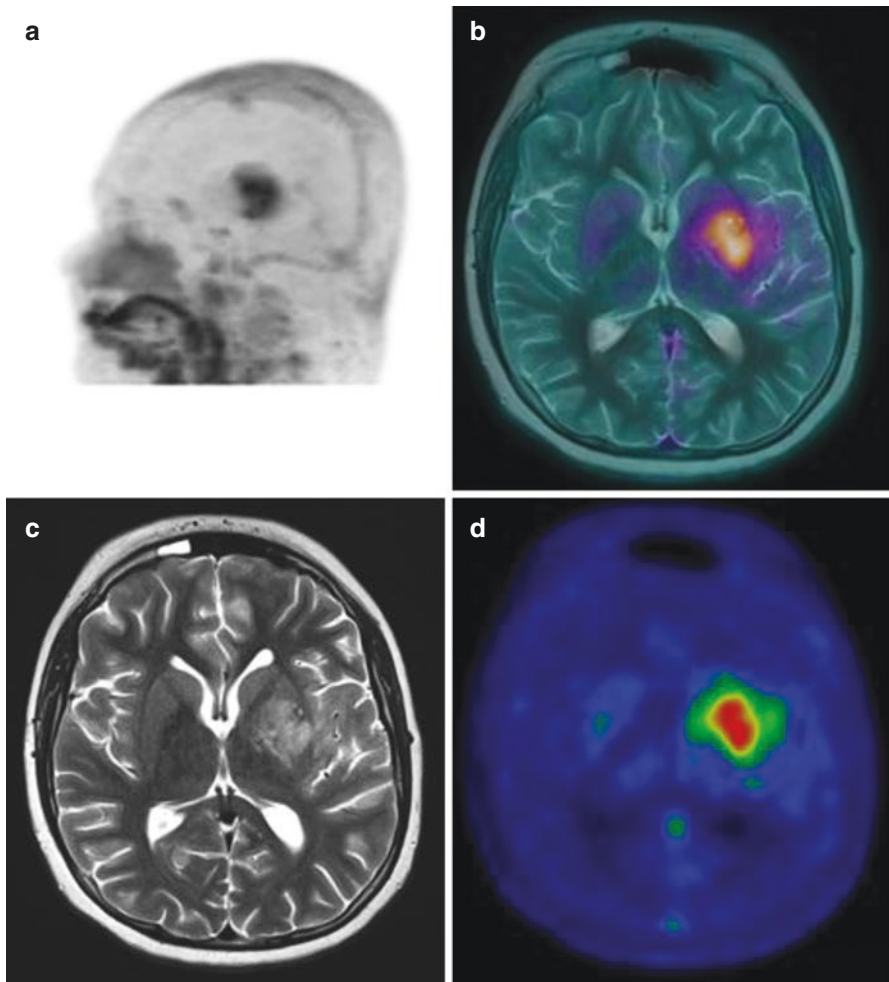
(a) MIP, (b) Axial fused PET/MR, (c) Axial MRI, (d) Axial PET in a patient with glioma of the left thalamus ($^{18}\text{G-DOPA}$)
